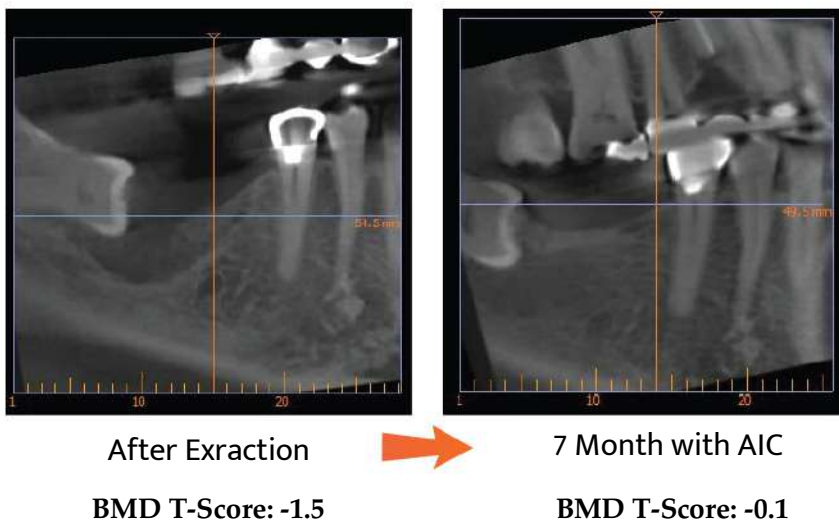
The X-Ray Image for An Asian Male Who is 59 Years Old Showed Dental Bone Growth After Treating AIC for 7 Months Without Any Treatment. (The T-Score for the Dental Bone is Significantly Improved)
